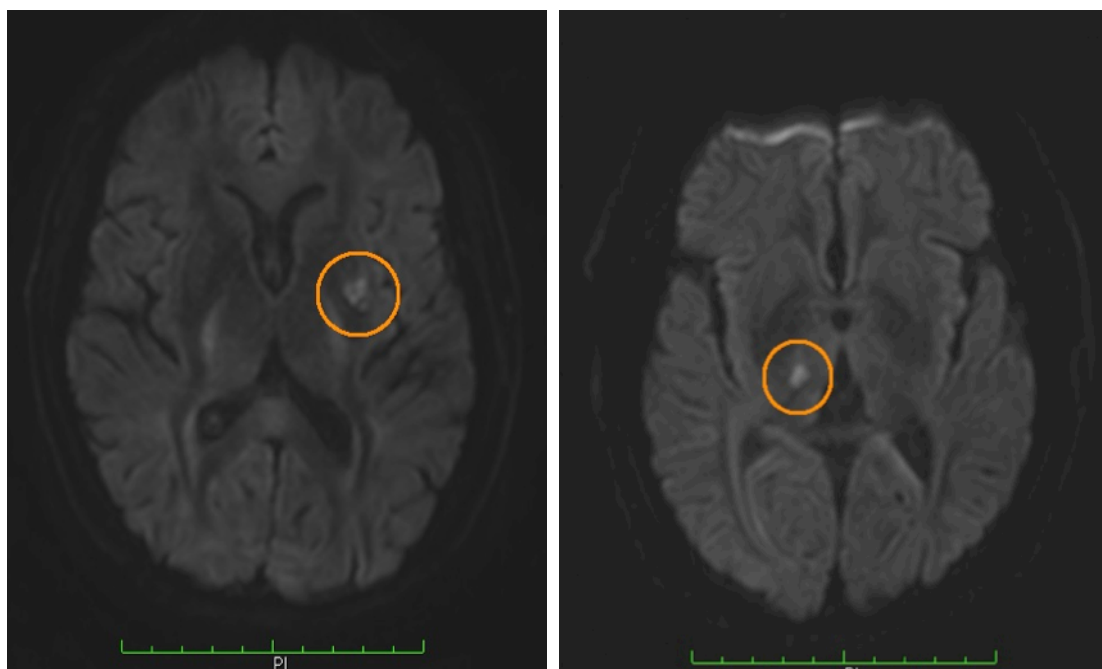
Diffusion Weighted Images (DWI) presenting with lesions from two representative patients
